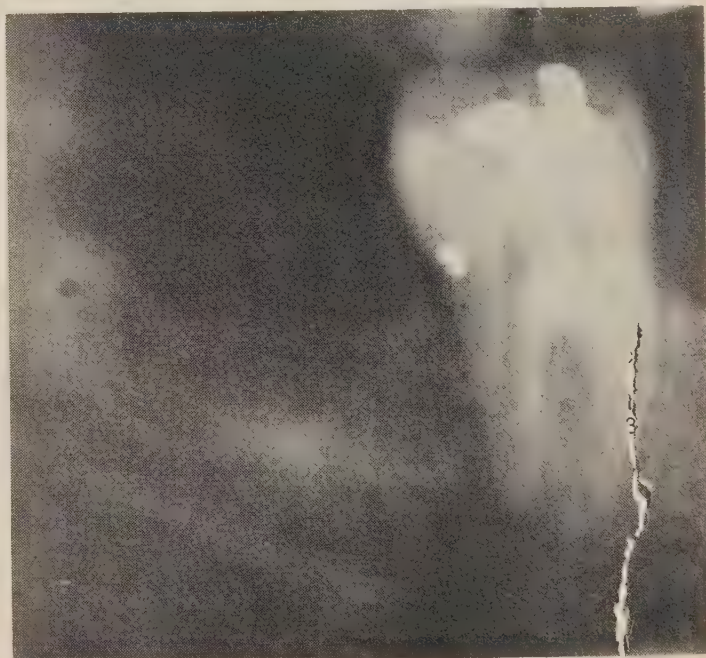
Postoperative radiograph (July 14, 1967) shows radiolucent area at apex of second molar.
